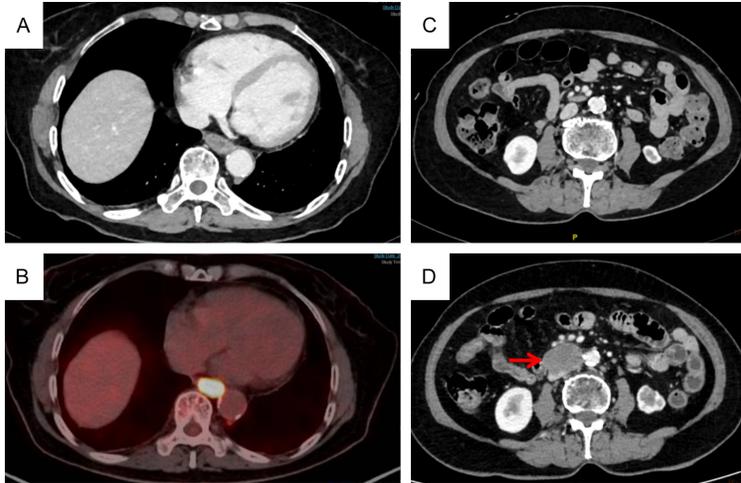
Initial imaging findings of the esophageal large-cell neuroendocrine carcinoma case. A. Enhanced computed tomography (CT) imaging revealed thickening of the distal esophageal wall. B. Positron Emission Tomography (PET)-CT indicated a strip-like area of high metabolic activity in the distal esophagus, corresponding to the vertebrae at thoracic levels 9 and 10. C. Follow-up CT scans showed initial response to chemotherapy and radiotherapy. D. Follow-up CT scans showed disease progression with the development of abdominal lymph node metastases on imaging follow-up 18 months later.
